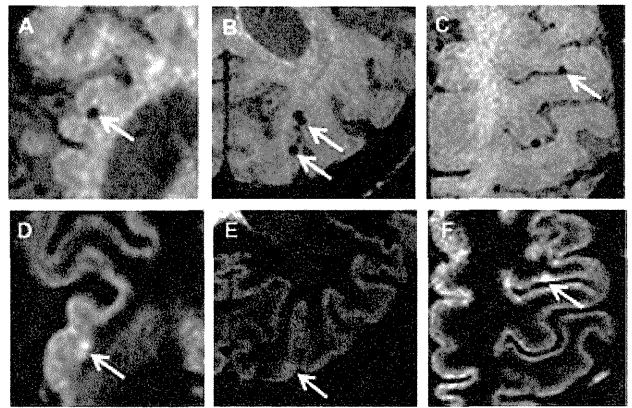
Higher magnification of head MR images in a 41-year-old woman with familial AD (Patient 2). Spatial close association is shown between intracortical high signal lesions on DIR (D, E, F) and lobar CMBs (A, B, C).
